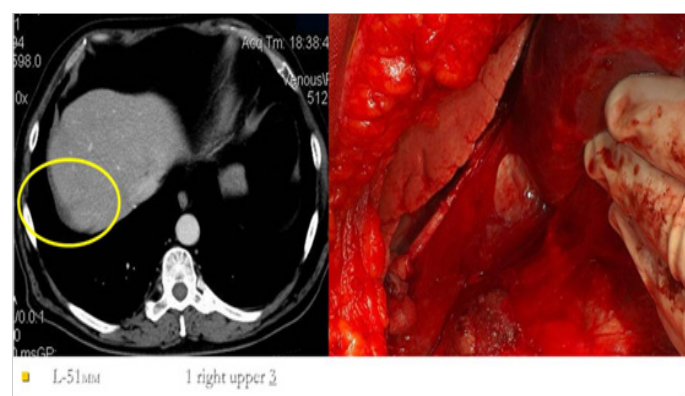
Implants of abdominal surface of the right diaphragm on CT scan and intraoperative image.
